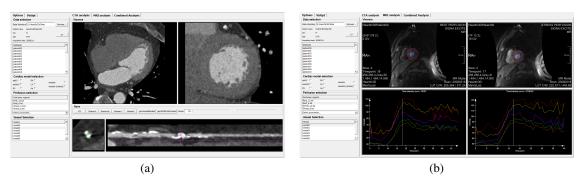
(a) CTA analysis GUI panel - Axial view of CTA data (top left), short-axis reformatted view (top right), CPR view of the selected vessel (bottom) - (b) CMR perfusion GUI panel - Rest/stress CMR perfusion data (top), rest/stress time-intensity curves (bottom). On the left side, there are 2 panels: 1) to navigate in the data (change patient, display patient information and reports, select specific artery, specific perfusion parameter ...) and 2)to control the visualization (change perfusion color, display heart model, show 2D/3D viewers, overlap coronary arteries on 2D BEP, add clip-planes,...).
